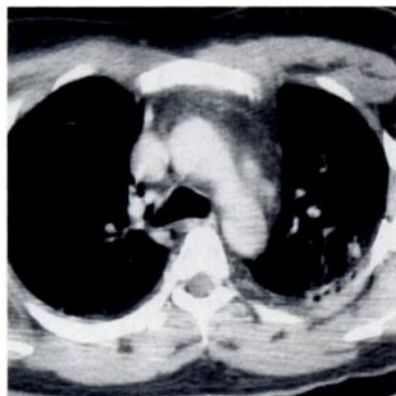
Findings equivocal for mediastinal hematoma. Contrast-enhanced CT scan of chest shows streaks of density in anterior mediastinal fat in a 34-year-old man involved in a high-speed motor vehicle accident. Aortographic findings were interpreted as normal.
